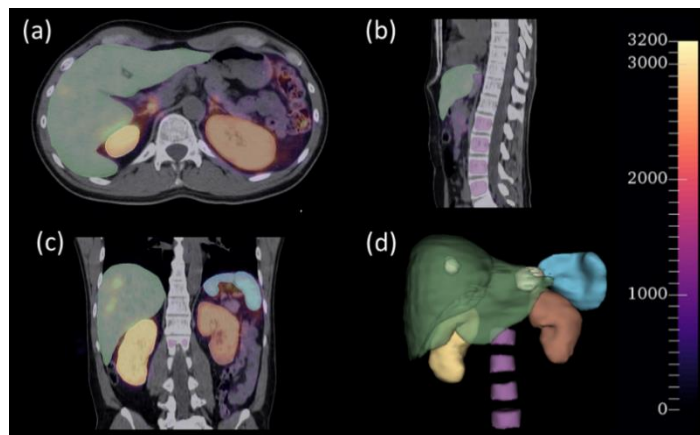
(a) axial, (b) sagittal and (c) coronal projections of the VOIs (liver, spleen, kidneys, bone marrow and NETs) of patient #3 in the 1<sup>st</sup> treatment cycle, superimposed to the SPECT scan acquired 24 h PI fused with the respective CT scan. (d) 3D representation of the segmented VOIs. Green: Liver; Yellow: Right Kidney; Brown: Left Kidney; Blue: Spleen; Purple: Bone Marrow; White: NETs.
